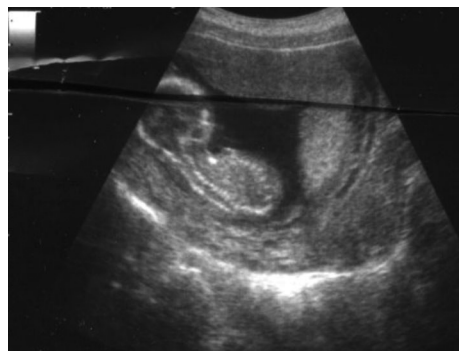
Ultrasound of baby.
